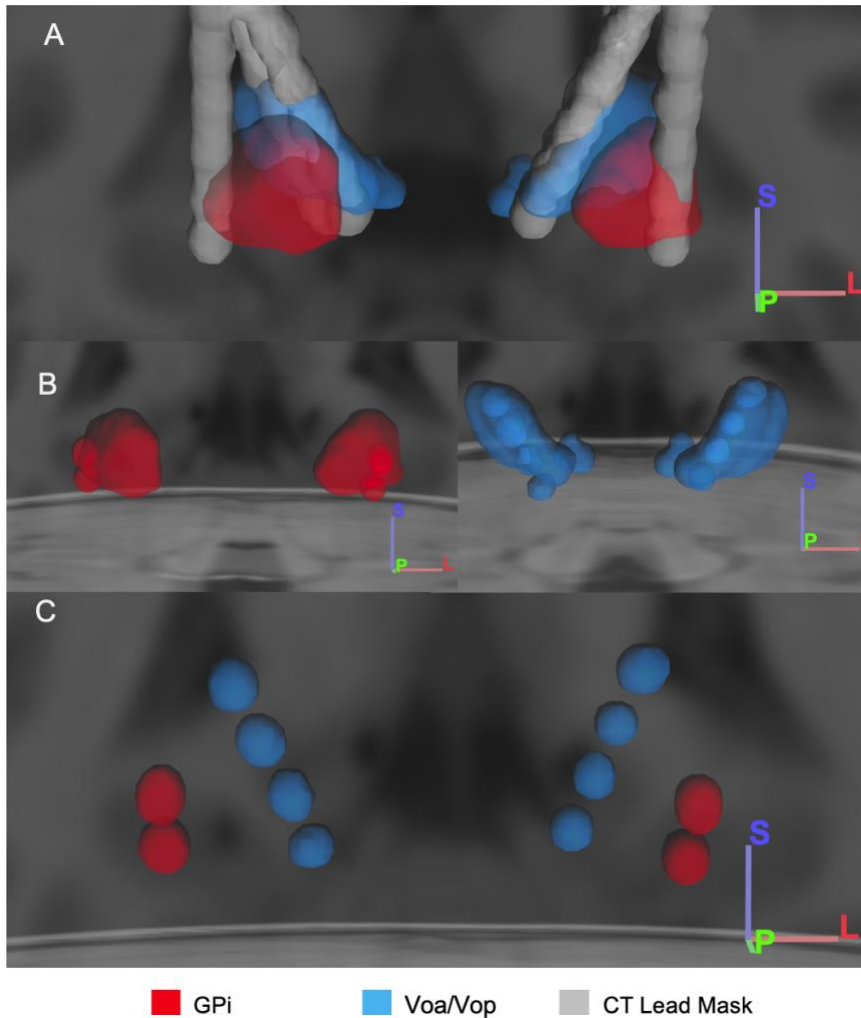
Visualization of the steps to determine source and target regions for tractography analysis. (A) DISTAL atlas normalized to individual anatomy, showing leads (gray) in deep brain regions corresponding to globus pallidus internus (GPI, red) and ventral oralis anterior/posterior (Voa/Vop, blue). (B) Spatial conjunction analysis between the CT scan and deep brain regions to determine which parts of the DBS electrode that are placed within GPI and Voa/Vop. (C) Source (red) and target (blue) region selection based on the conjunction analysis between the CT scan and atlas.
